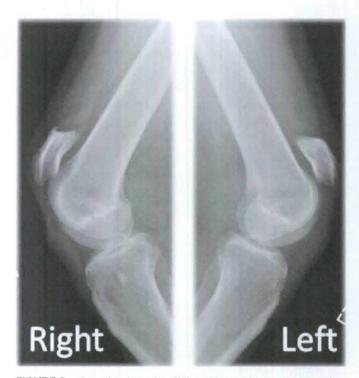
Lateral radiographs of bilateral knees taken upon presentation.
